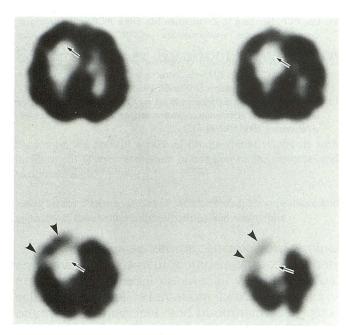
Axial images of single-photon emission CT with ¹²³I-IMP taken 15 minutes after intravenous injection of ¹²³I-IMP. Note the defect of ¹²³I-IMP activity, representing the nidus itself (*arrow*) and the decreased local cerebral blood flow around the malformation (*arrowheads*).
